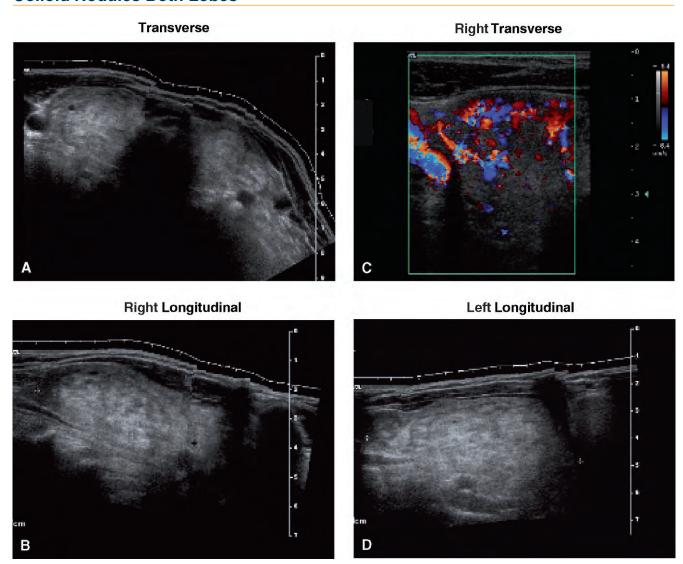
Ultrasound of colloid nodules in both lobes. A, Transverse. B, Right lobe longitudinal, sagittal diameter (SD): 57 mm. C, Color Doppler. D, Left lobe longitudinal, SD: 78 mm.
